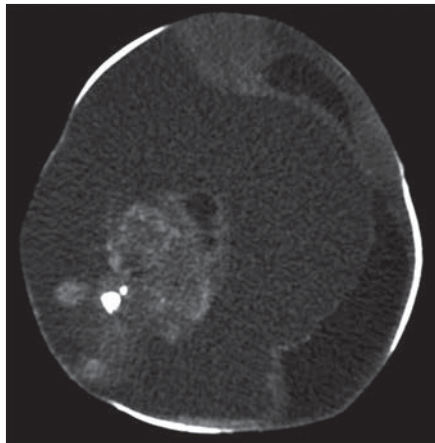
2-day-old boy with congenital intracranial teratoma. Axial CT image shows heterogeneous solid and cystic attenuation with mixed calcified and fat components. Diastasis of sutures is evident. (Courtesy of Dupree B, Overton-Brooks VA Medical Center, Shreveport, LA)
